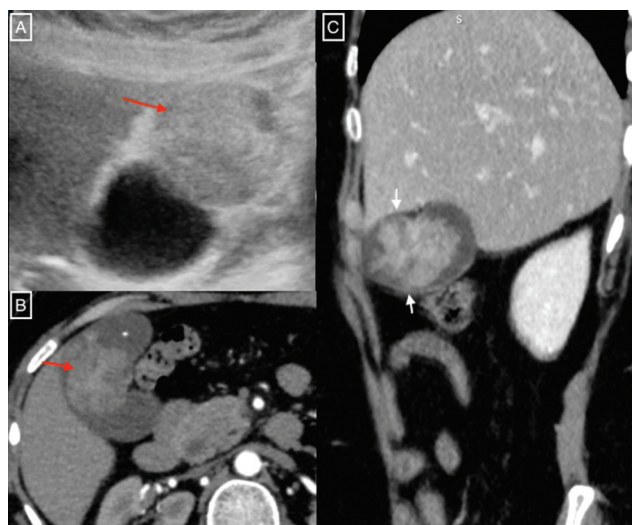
A 45-year-old female with malignant polypoidal gallbladder lesion (biopsy-proven adenocarcinoma of the gallbladder). Grayscale ultrasound image shows the echogenic polypoidal lesion within the gallbladder lumen (A). Axial contrast-enhanced computed tomography image shows heterogeneous contrast enhancement of the polypoidal lesion (B). Note the lesion is confined within the gallbladder lumen (arrow, C).
